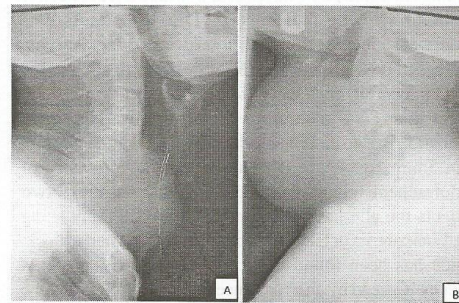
Lateral neck radiographs of two patients with tracheal column of lucencies (tracheal internal diameter) less than 5mm. Both patients had failed intubation. Note the marked tracheal compression and narrowing from goiter in both patients.
